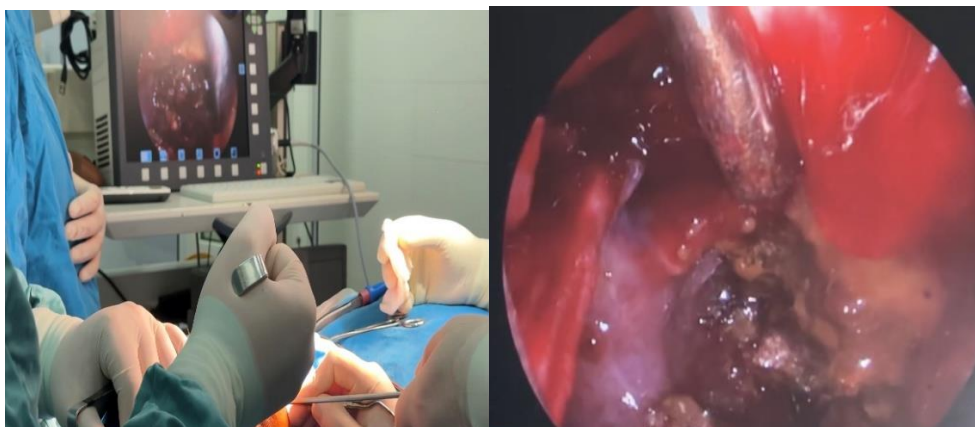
Navigation-guided tumor resection with endoscopic assistance. (A) Intraoperative navigation system demonstrating registration of the patient to the preoperative three-dimensional CT dataset and real-time localization of the surgical instruments. (B) Endoscopic inspection of the surgically treated maxillary region, demonstrating visualization of anatomically restricted areas following tumor resection.
